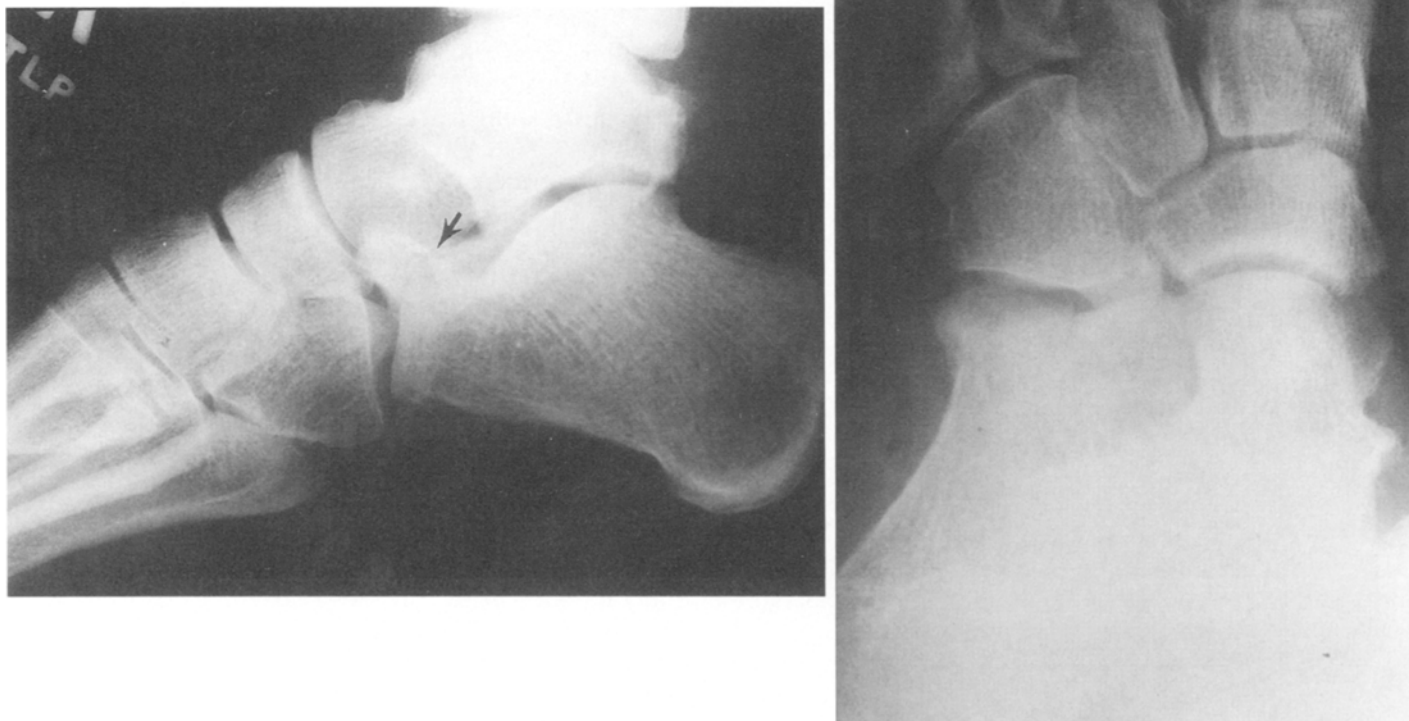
Impaction fracture of the anterior process of the calcaneus. Left, lateral radiograph shows a fracture of the anterior process of the calcaneus (arrow), extending to the calcaneocuboid joint. Right, oblique radiograph of the foot better shows the articular stepoff of the calcaneocuboid joint. This fracture is due to impaction of the calcaneus on the cuboid bone and differs from the avulsion of the anterior process related to bifurcate ligament traction.
